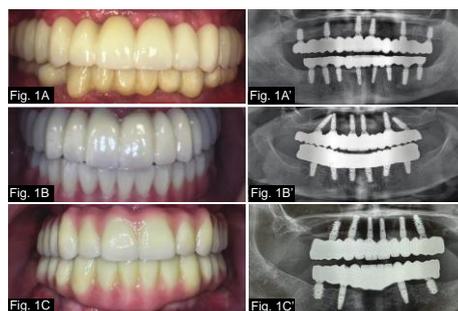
Intraoral photographs of FP1 implant-supported prostheses (A) and corresponding panoramic radiograph (A’), FP2 implant-supported prostheses (B) corresponding panoramic radiograph (B’), and FP3 implant-supported prostheses (C) and corresponding panoramic radiograph (A’), FP2 implant-supported prostheses (C’). Implant surgery and restorations performed by author in private practice setting in Berkeley, CA, USA.
